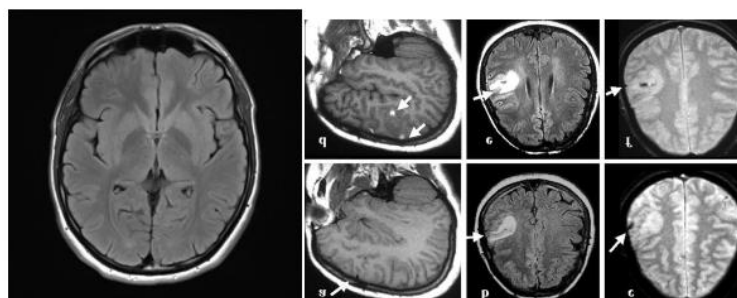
Normal brain MRI vs MRI of brain with Thrombotic Cerebral Infarction.¹⁰
